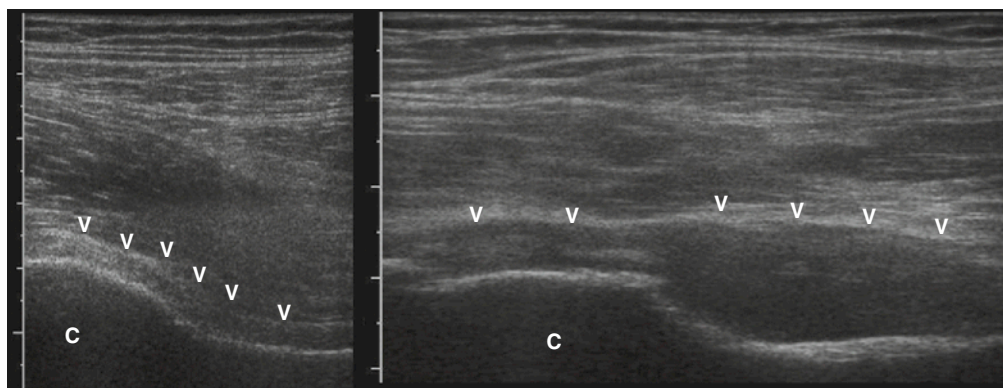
NORMAL AND ARTHRITIC HIP JOINTS. The ultrasound scans of a normal hip joint (*left*) and an arthritic hip joint (*right*) show the contour of the capsule (arrowheads) and the femoral head (C). In the normal joint, the capsule follows the anatomy of the joint, whereas in the pathologic hip, synovial hypertrophy makes the capsule bulge outward.
